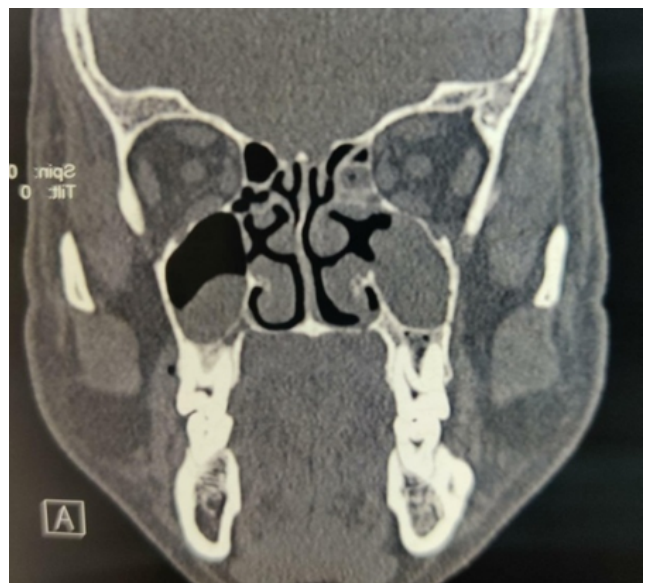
CT scan face report revealed an mucosal thickening noted in right ethmoid, bilateral maxillary and sphenoid sinuses suggestive of fungal sinusitis.
